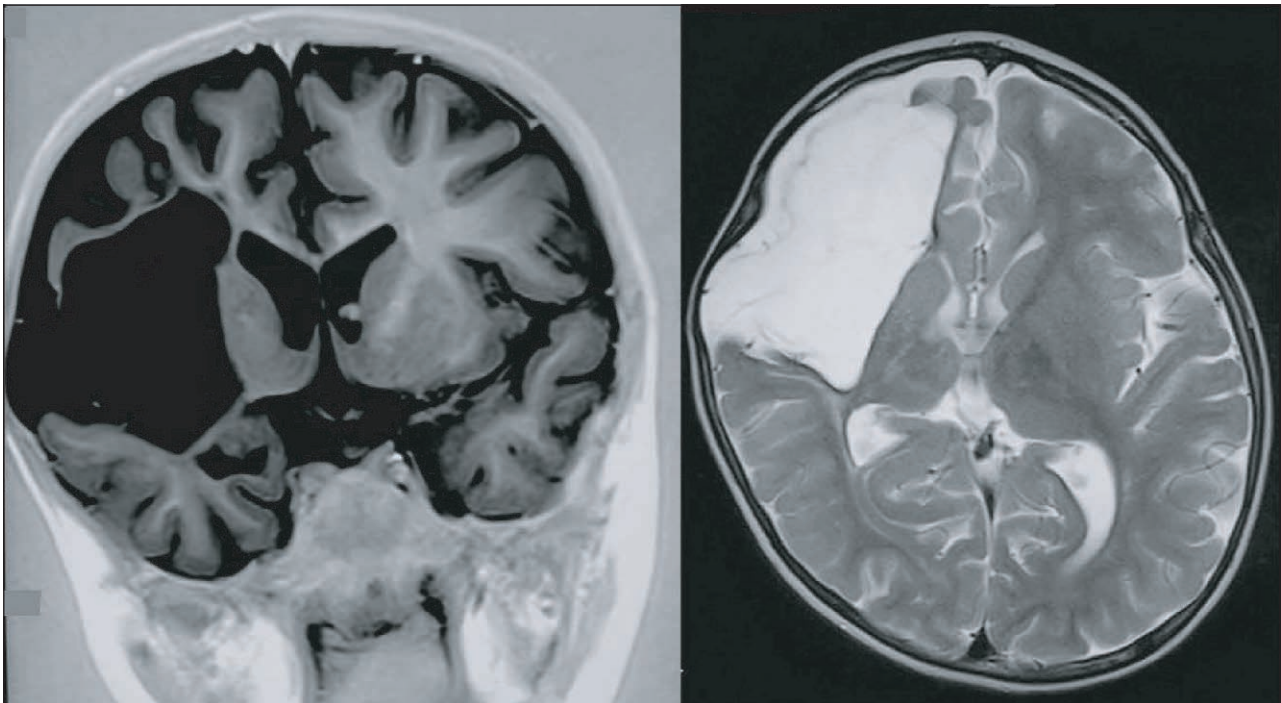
Cerebral MRI showing a large sequellar lesion in the right middle cerebral artery territory, sparing the thalamus.
